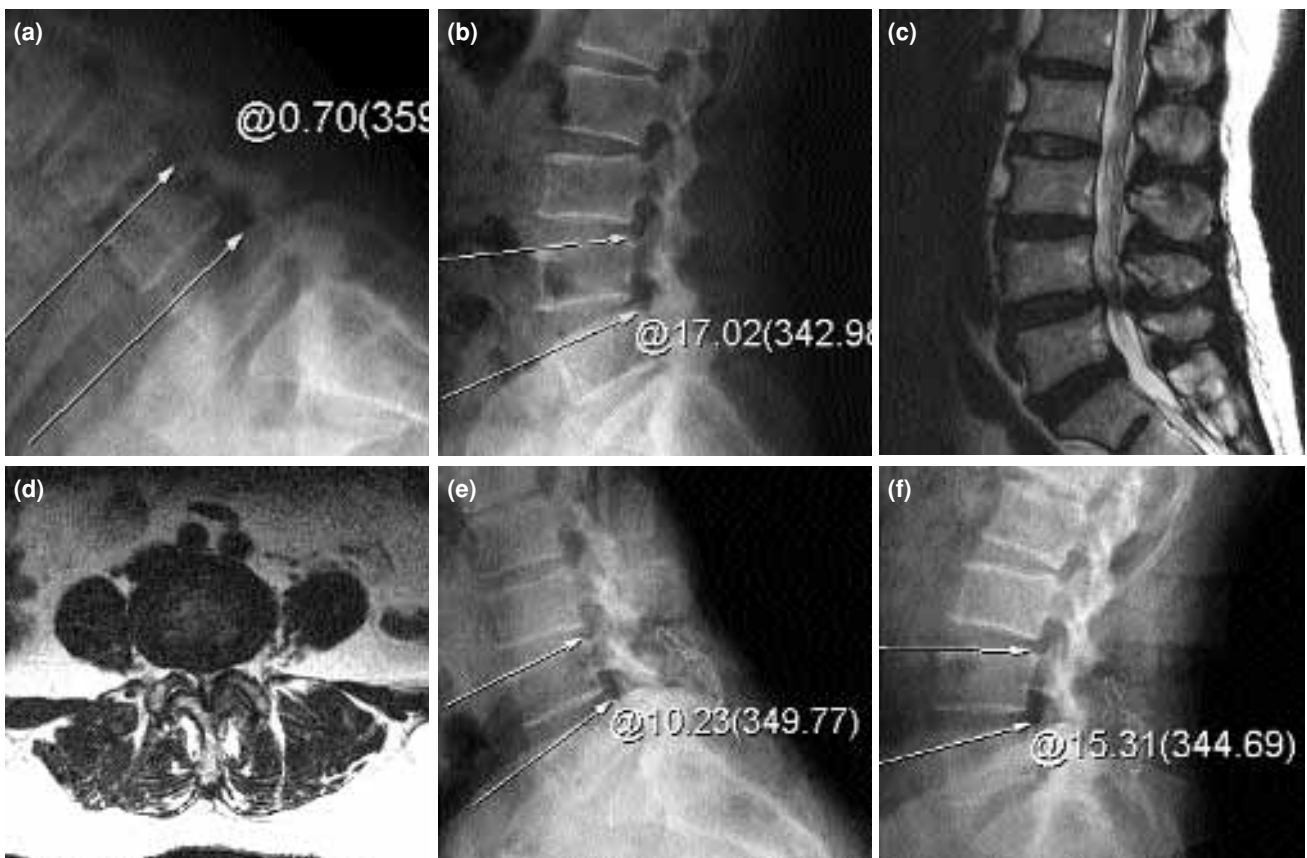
(a, b) Preoperative images showing instability and a synovial cyst. The sagittal rotation angle (SRA) is measured as 17 degrees. (c, d) Appearance of the synovial cyst at L₄₋₅ on an MR image. (e, f) Postoperative images showing improvement in instability, with SRA being 5°.
